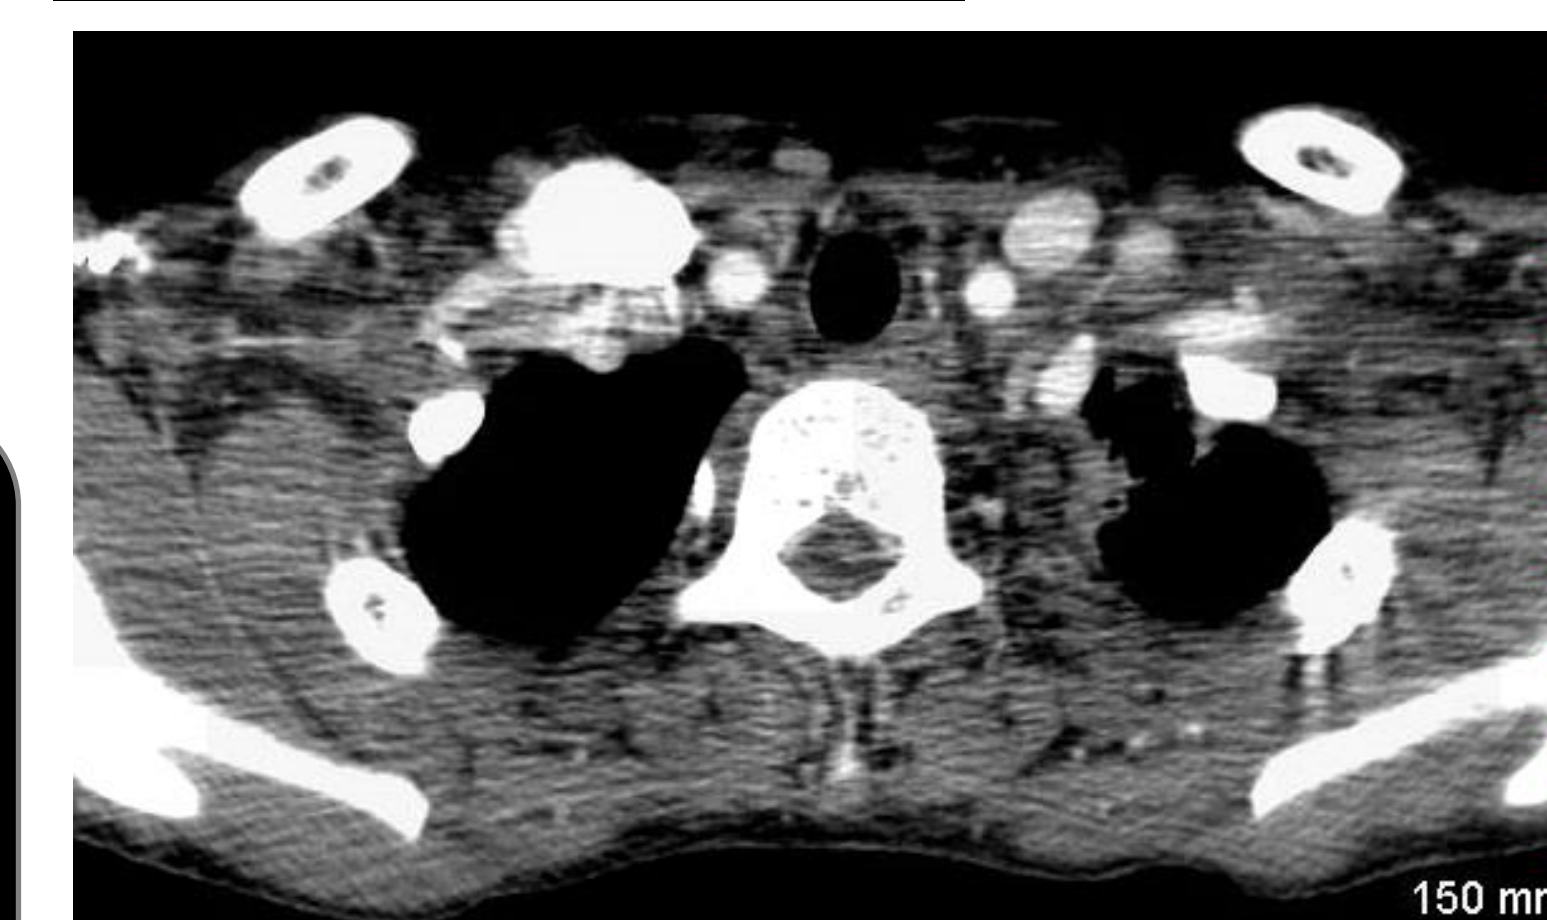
(above). CT image with small infiltrate in left upper lobe noted
